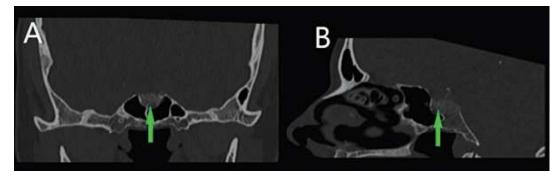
(A and B). CT scan of the paranasal sinuses using a bone window. Panel A shows a coronal slice of the tumor with intensity identical to that of bone. Panel B displays a sagittal slice of the osteoma and its infiltration into the clivus and the floor of the sella turcica. The green arrow in both images indicates the tumor
